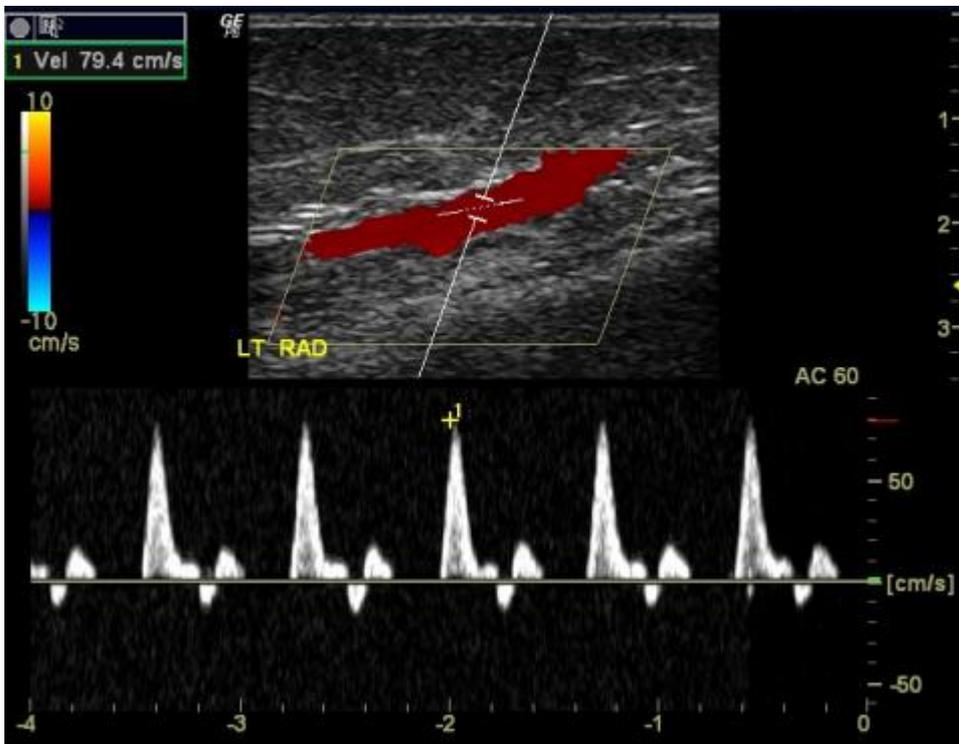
Normal radial artery spectral Doppler. Constructing an AV fistula with a diseased or low-flow radial artery can increase the chances of physiologic steal.
